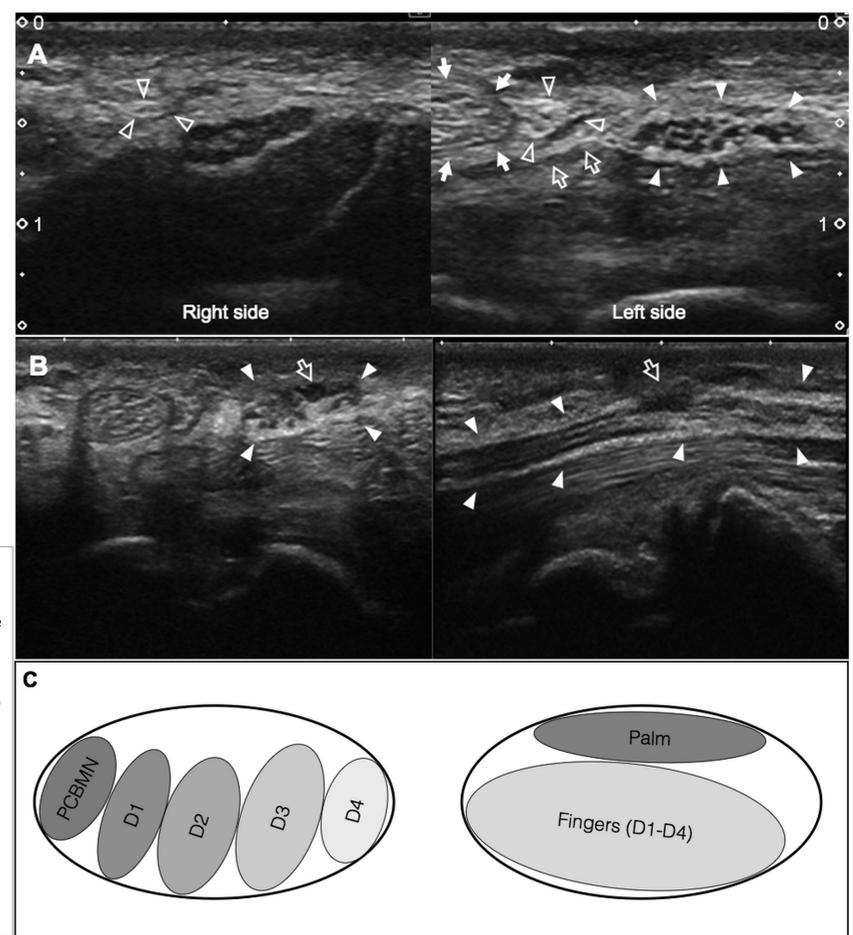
Nerve ultrasound findings. A. The cross sectional area (CSA) of the left palmar cutaneous branch of the median nerve (PCBMN, open arrowheads) was larger (3 mm²) than that of the left PCBMN (1 mm²) and to normative data. Closed arrowheads indicate the median nerve (MN); open arrows indicate the flexor retinaculum; closed arrows indicate the flexor carpi radialis tendon. B. The axial scan of the left MN (closed arrowheads) in the carpal tunnel, distal to the point where the PCBMN left the main nerve trunk, showed a superficial fascicular hypoechoic enlargement (left panel, open arrow), which appeared as a lateral neuroma with epineurial loss-of-continuity on the longitudinal scan (right panel, open arrow). C. The somatotopical arrangement of MN fascicles. Left panel shows the lateral-to-medial distribution according to autopsy studies. Right panel indicates the possible proximal-to-distal fascicular arrangement, as suggested by our patient. D1 = thumb finger, D2 = index finger, D3 = median finger, D4 = ring finger.
